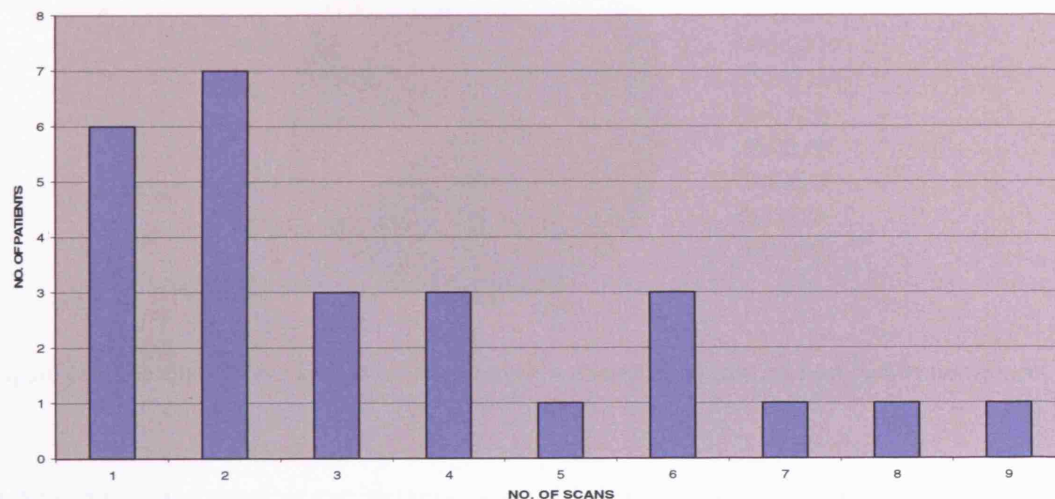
Number of patients for whom specific numbers of MT MRI examinations remained for analysis after image quality control process
